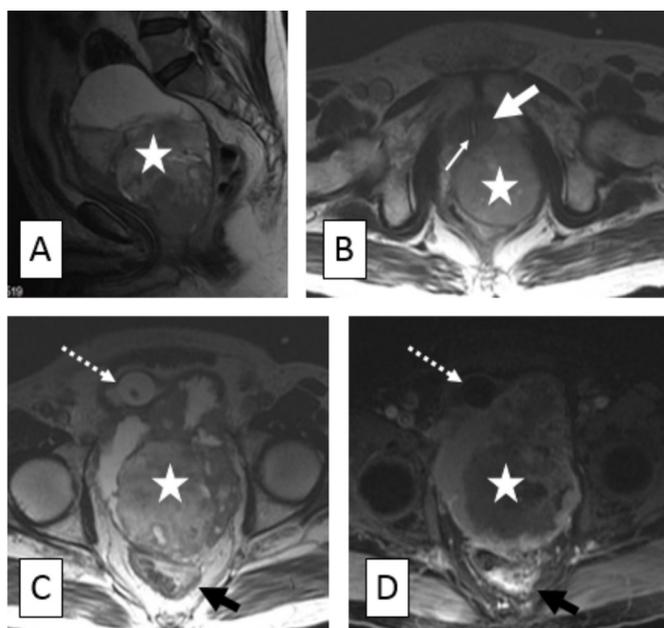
MRI examination; A. Sagittal T2 weighted image, B. Transverse T2 weighted image at the the pelvic floor, C. Transvers T2 weighted image, D. Transverse contrast-enhanced T1 weighted image.
